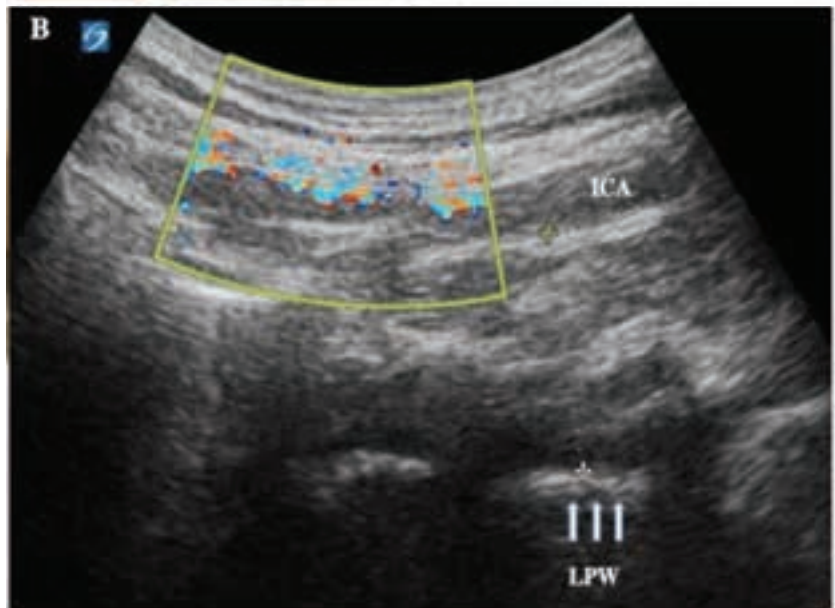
Ultrasonographic measurement of LPWT. A. Scanning position to obtain LPWT measurement. With the patient supine, a high-frequency curvilinear probe was placed on the lateral neck in the longitudinal plane. B. Identification of the ICA was assisted with color Doppler imaging, and the lateral wall of the pharynx was visible as a hyperechoic interface (arrows). Distance was measured from the internal border of the ICA to the LPWT.
